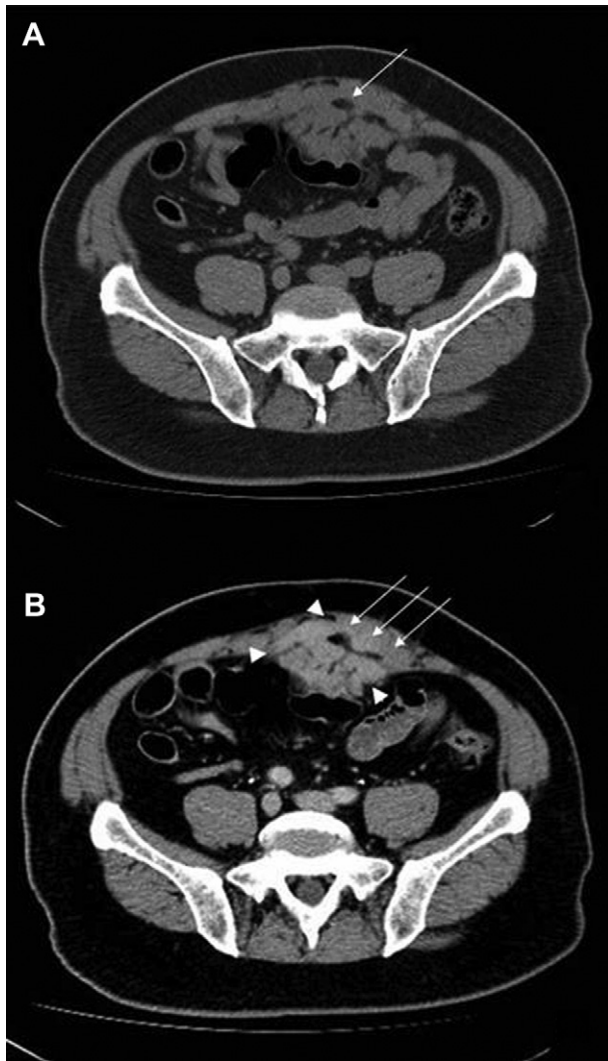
(A) Noncontrast CT in axial view reveals a mass with fat inclusion (–90 HU, arrow) and no calcification at the midline of the lower abdomen. (B) Contrast-enhanced CT in axial view shows an ill-defined heterogeneously enhancing mass (arrowhead) at the midline of the lower abdomen. The tissue plane between the mass and the rectus abdominis muscle is not clear (arrow), which is suggestive of abdominal wall invasion. CT = computed tomography.
